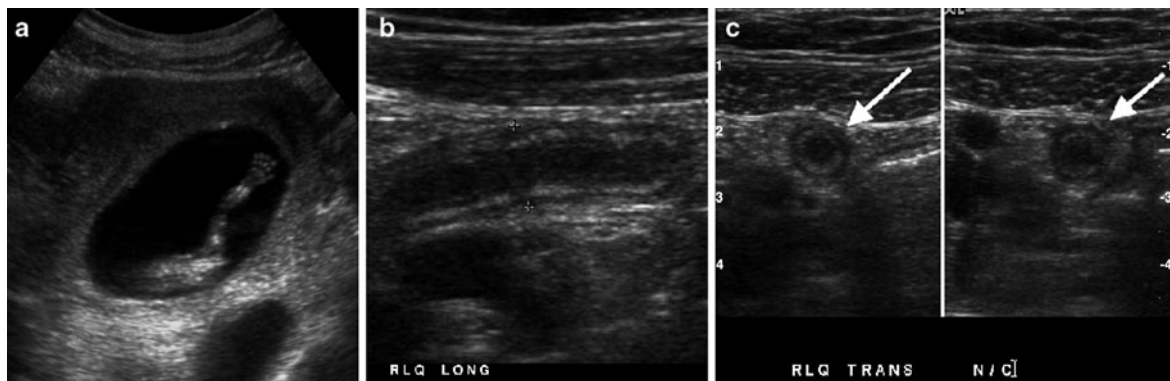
Ultrasound of 13-week pregnant patient with right lower quadrant pain, rule out acute appendicitis. a Ultrasound image of uterus shows intrauterine pregnancy, b Longitudinal image in the right lower quadrant shows a dilated appendix
